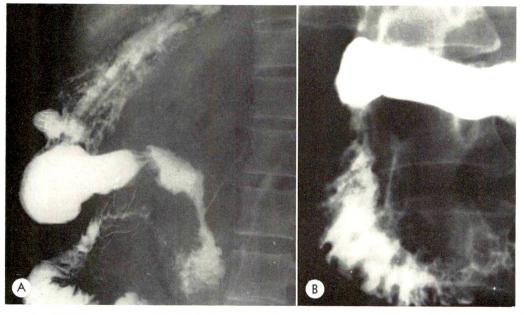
(A and B) Two roentgenograms are shown from the examination of a patient with acute pancreatitis, done 10 days after the onset of symptoms. Mild pain was still present. Persistent narrowing of the upper descending duodenum was evident at fluoroscopy. Edema of duodenal mucosa is apparent. The upper gastrointestinal tract appeared normal on examination 3 weeks later.
